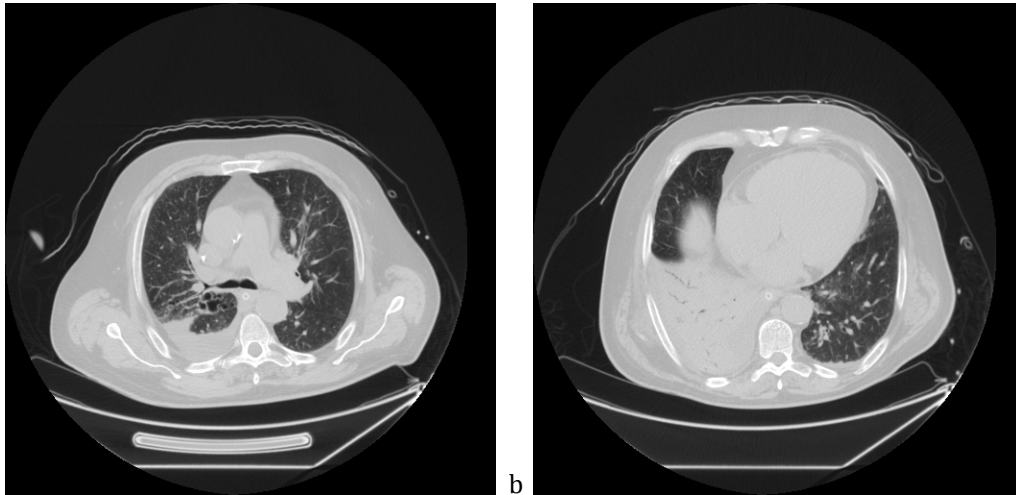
05/10/2020. Computed tomography, axial section. Lung window. Incision at the level of the tracheal bifurcation
